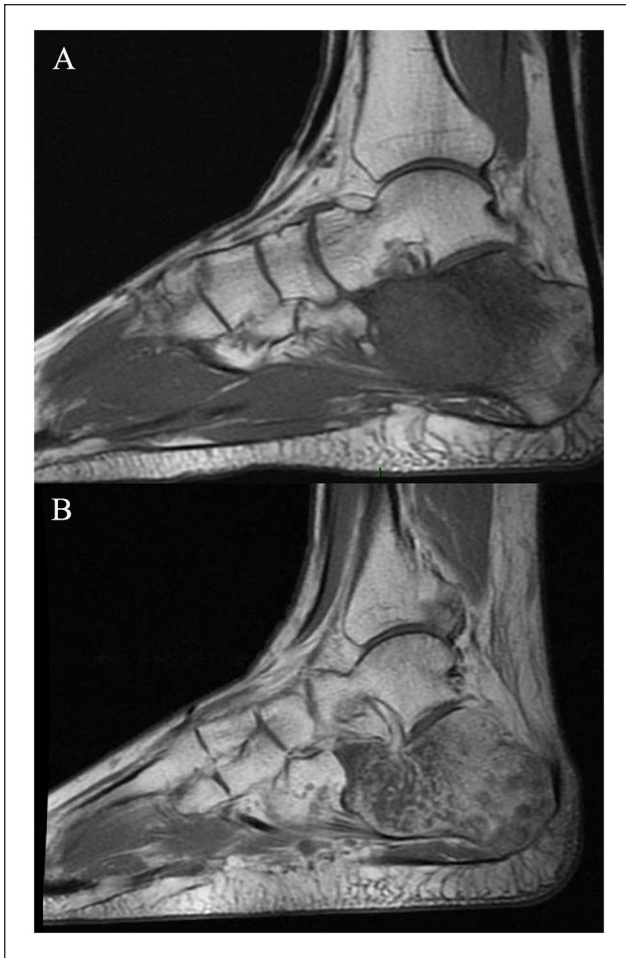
(A) Preoperative sagittal T1-weighted magnetic resonance imaging and (B) after gadolinium administration with a chondrosarcoma in a 39-year-old male patient with Ollier disease.
